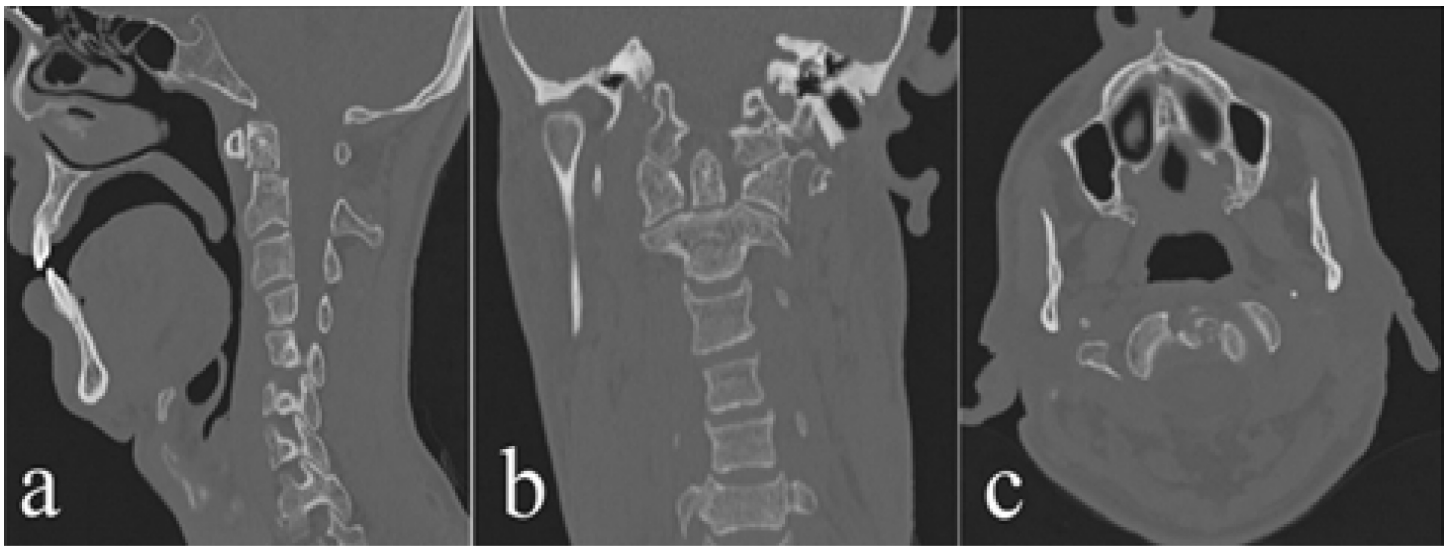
CT cross-sectional view of a C2 odontoid fracture case
